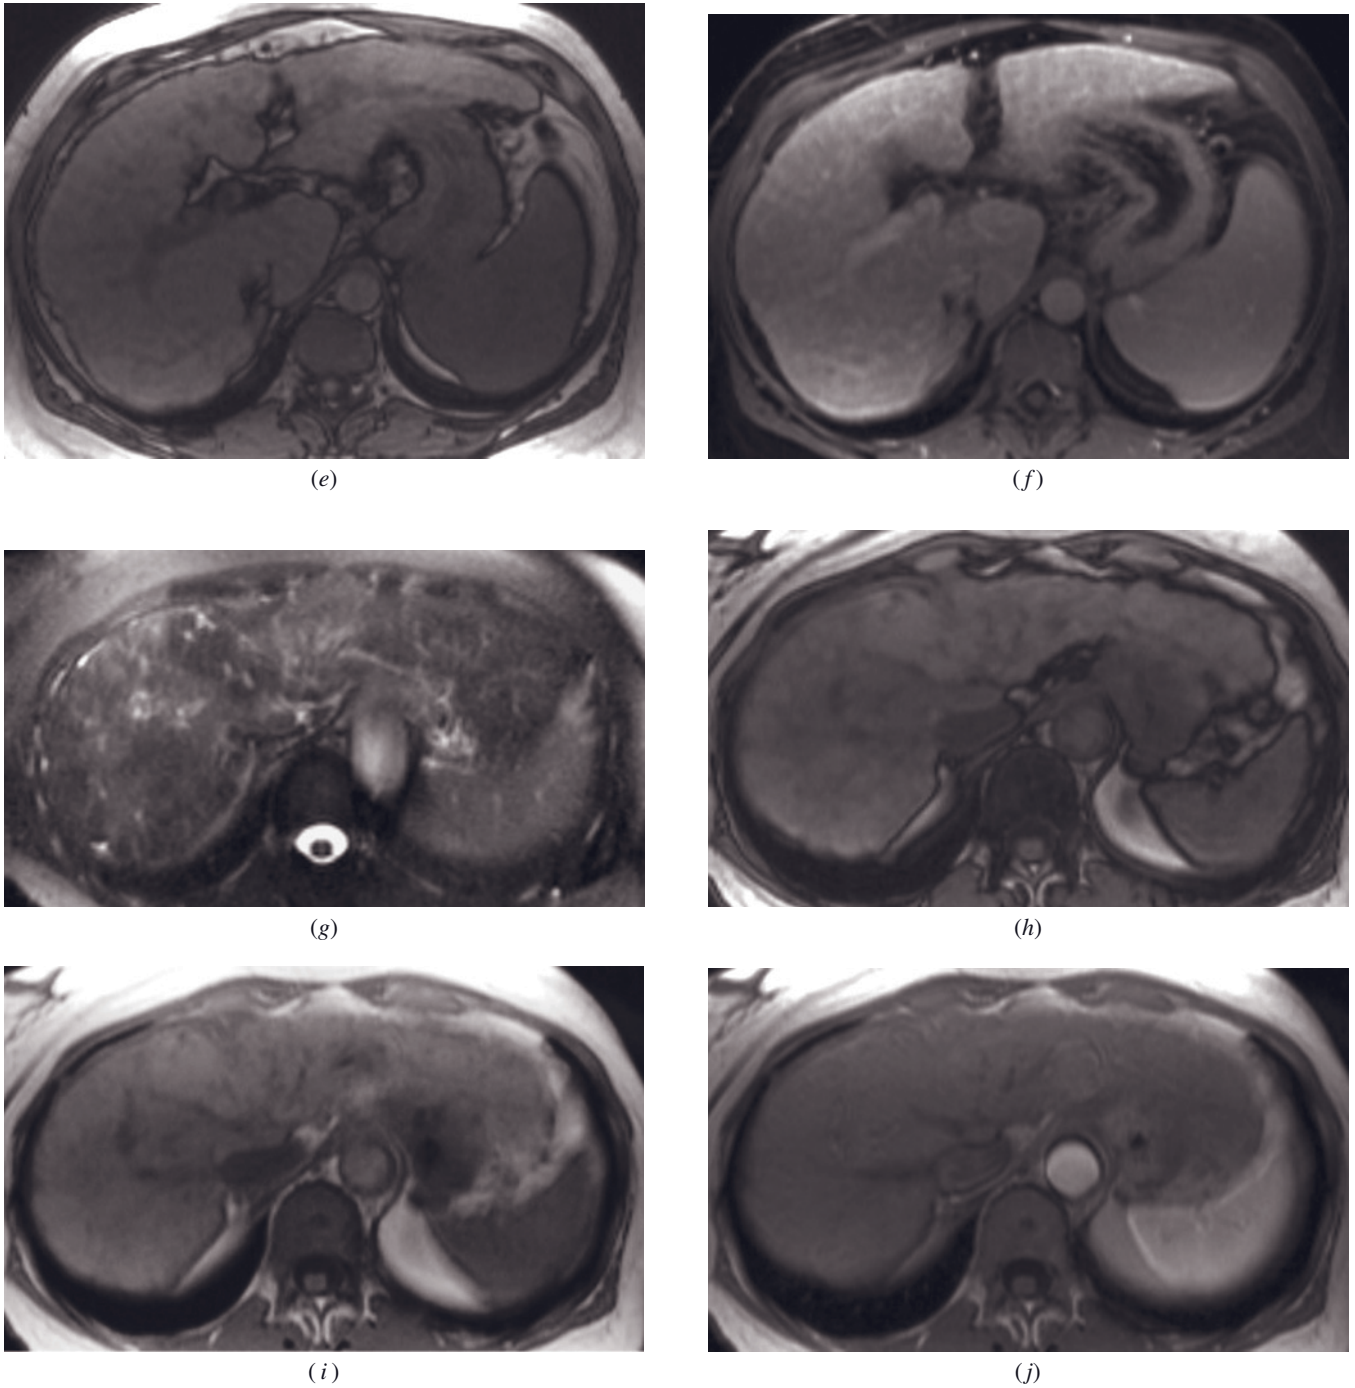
(Continued) T2-weighted SS-ETSE (g), out-of-phase SGE (h), in-phase SGE (i), and immediate (j), 60-s (k) and 90-s (l) images in another patient demonstrate diffuse fibrosis that exhibits progressively intense enhancement over time. T2-weighted SS-ETSE fat-suppressed (m), SGE (n), and immediate (o) and 90-s fat-suppressed postgadolinium SGE (p) images in a patient with untreated AIH at presentation. Note the early patchy enhancement reflective of acute inflammatory disease. AIH is characterized by a prominent network of fibrosis even early in the course of disease (d, f). The hepatic changes are similar to PBC, and both AIH and PBC tend to have less architectural distortion than primary sclerosing cholangitis.
